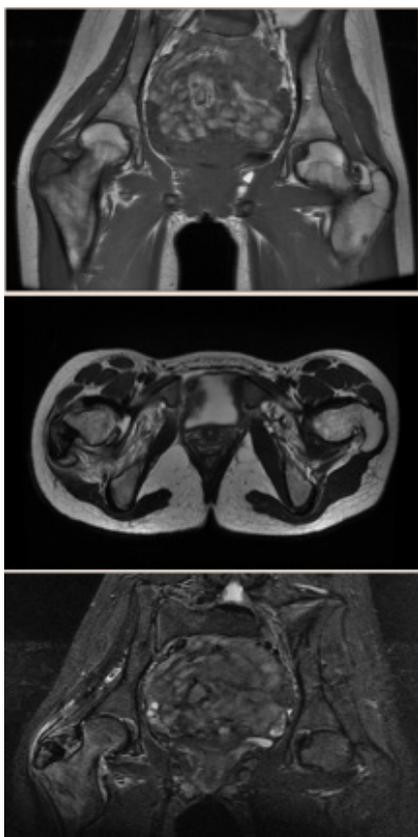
MRI scan showing increased signal in the bone marrow and perilesional tendons.
